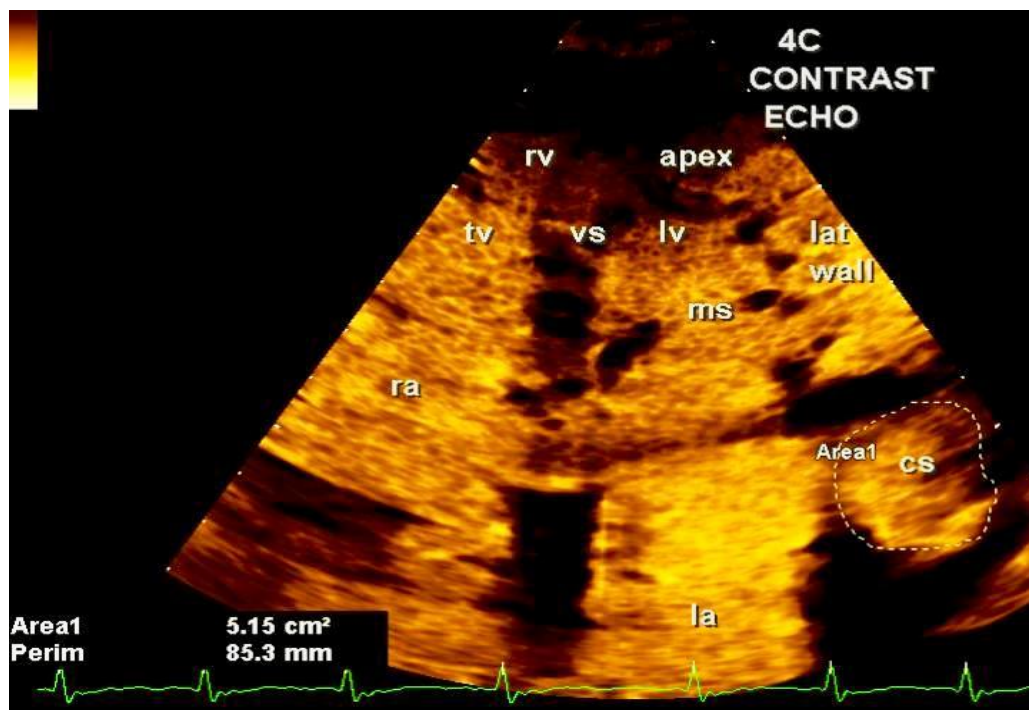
Contrast echocardiography in 4C view clearly demonstrates mitral stenosis, dilated right, left atrium and coronary sinus (cs) with dimensions.
